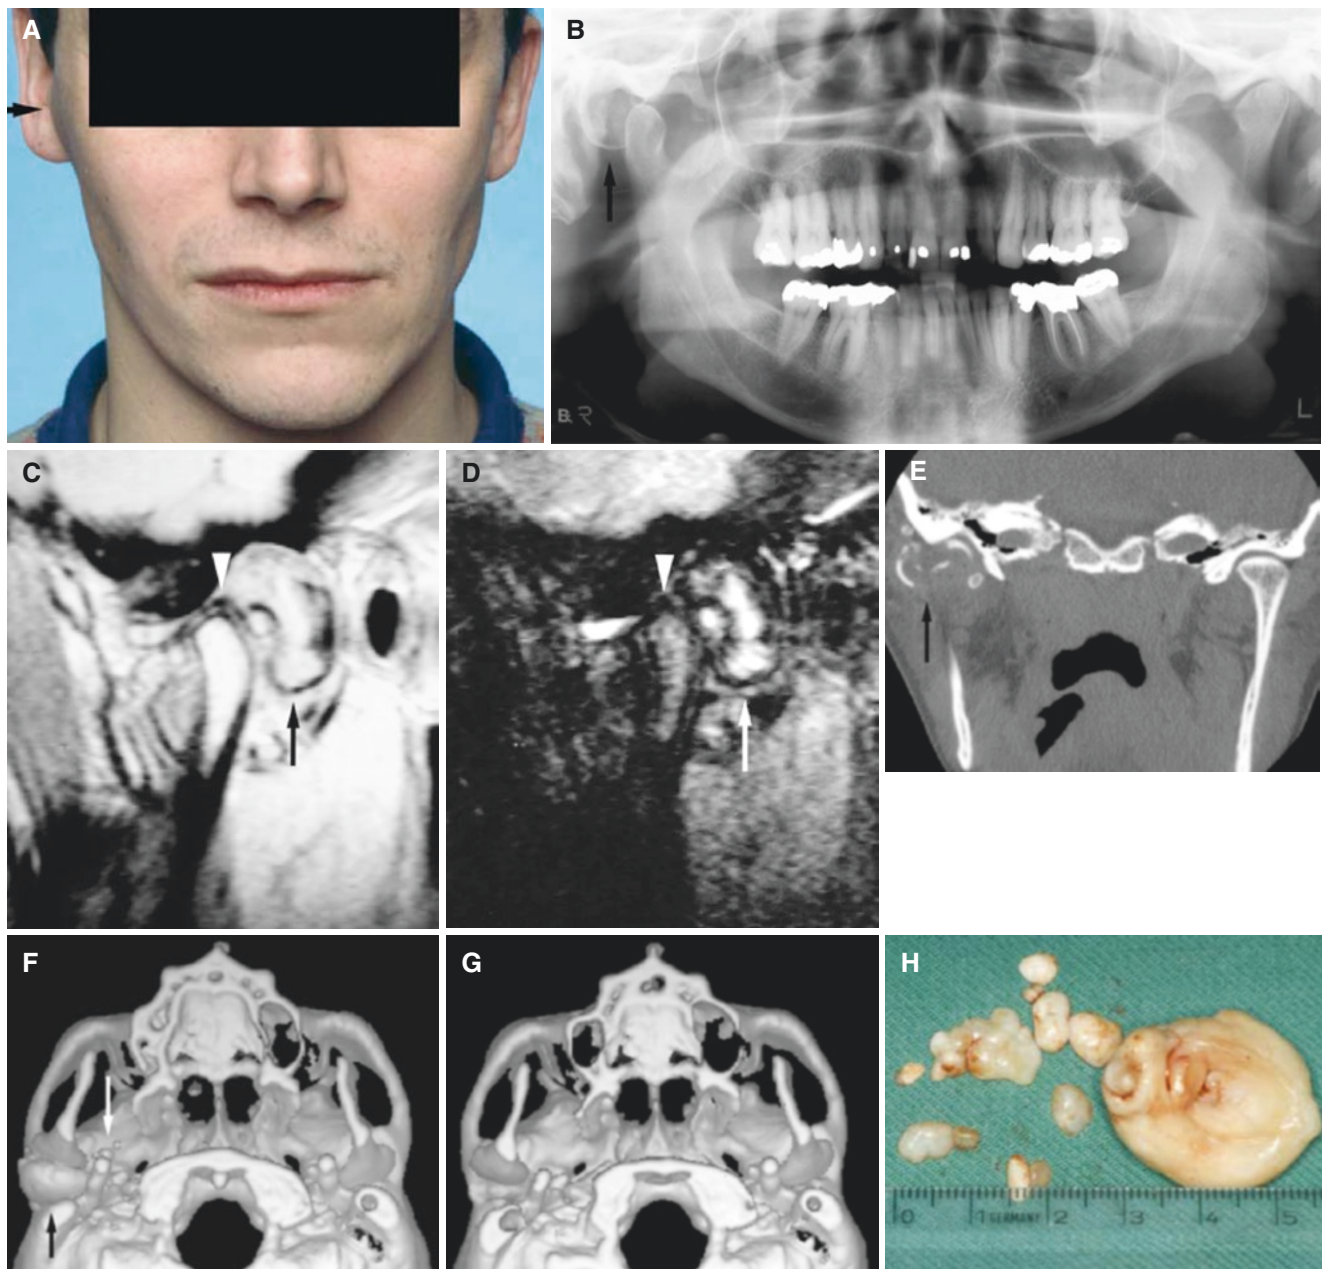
Synovial chondromatosis. (A) Clinical photograph shows facial asymmetry and swelling over the right joint (arrow). (B) Panoramic view shows large calcification (arrow) posterior to the condyle. (C) Oblique sagittal T1-weighted MRI shows large structure (arrow) posterior to the condyle, which is normal but displaced anteriorly with normal disc (arrowhead) at closed mouth. (D) Oblique sagittal T2-weighted MRI shows increased signal from expansive process
